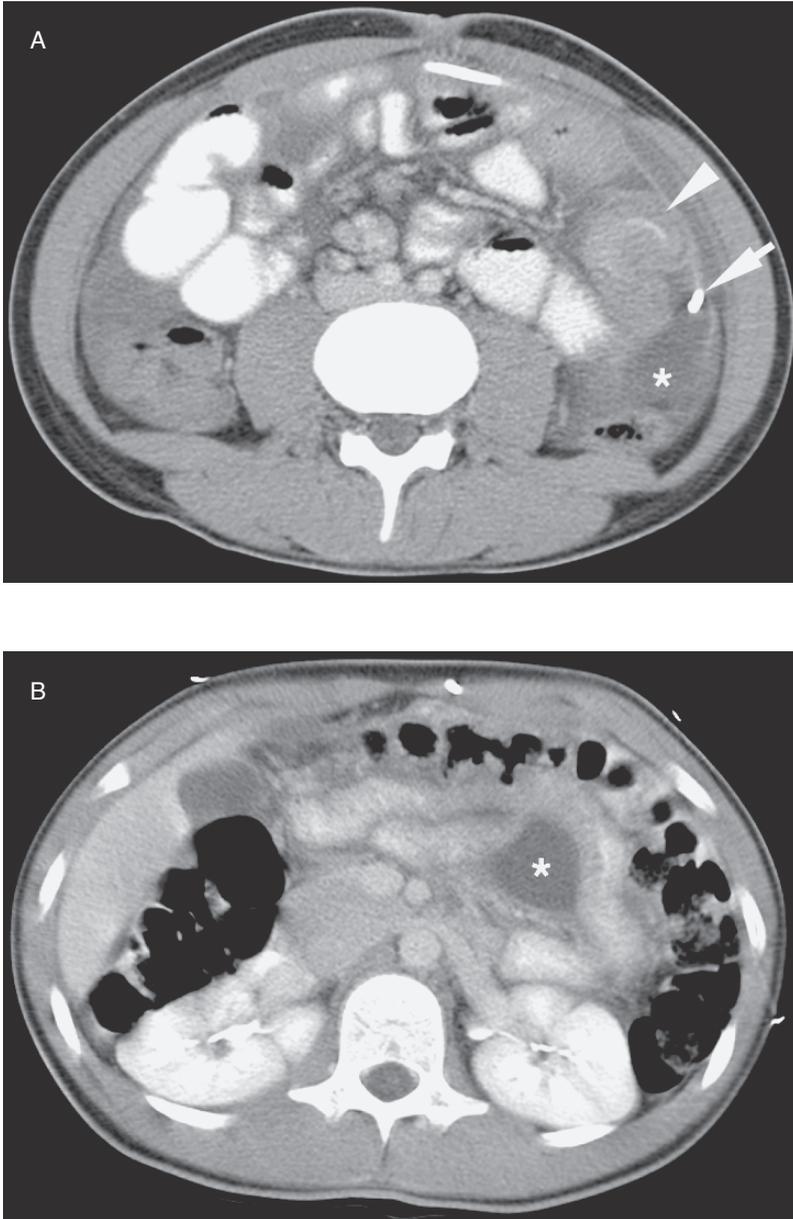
Intra-peritoneal infection. (A) Contrast-enhanced CT scan shows a focal fluid collection (*) associated with the VPS (arrow). There is associated bowel wall thickening (arrowhead) and peritoneal enhancement indicating infection. (B) Contrast-enhanced CT shows an interloop abscess (*).
